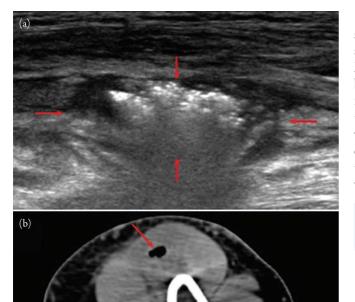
Soft tissue gas in myonecrosis. Panel (a) is a grayscale longitudinal sonographic image of the medial proximal arm showing an ill-defined region of heterogeneous echotexture (between the arrows). Numerous echogenic foci with so-called "dirty-shadowing" is the typical sonographic appearance of soft tissue gas. Panel (b) shows an axial computed tomography image of the arm shows the low density soft tissue gas (arrow) in the intramuscular phlegmon.
